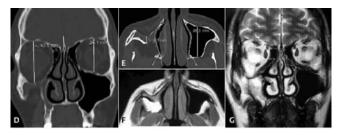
Preoperative D, E) CT in coronal and axial plane show atelectasis of the right maxillary sinus with anterior and posterior walls inward bowing, concavity of the orbital floor with resulting increase of the orbital volume. Measurement of the orbit from frontal bone to infraorbital nerve differs of 8.5 mm from left to right side. The anterior-posterior diameter of the maxillary sinus changes of 28.6 mm F) MR in axial plane shows inward bending of anterior and posterior walls with flattening of the cheek region and enlargement of the retroantral fat pad. Right maxillary sinus collapsed with signal intensity due to thick mucus filling. G) T2 weighted MR in coronal plane showing downward displacement of orbital content.
